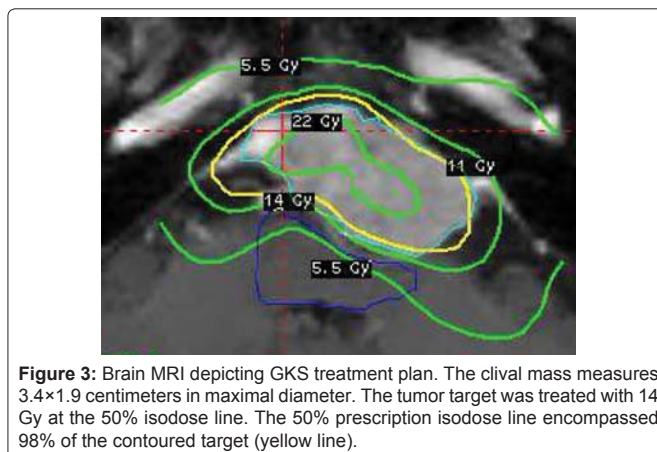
Brain MRI depicting GKS treatment plan. The clival mass measures 3.4×1.9 centimeters in maximal diameter. The tumor target was treated with 14 Gy at the 50% isodose line. The 50% prescription isodose line encompassed 98% of the contoured target (yellow line).
